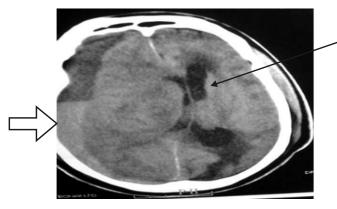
Axial brain CT showing right frontoparietal extracranial cresenteric bleed with fluidfluid level and dependent hyperdense component (white arrow). Note associated significant subfalcine herniation (black arrow) to contralateral side. (Acute-on-chronic subdural haematoma).
